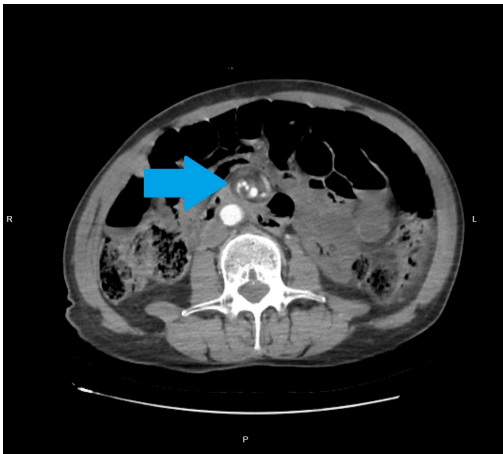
An axial CT image shows the typical whirlpool sign (the blue arrow) and a distended small bowel
